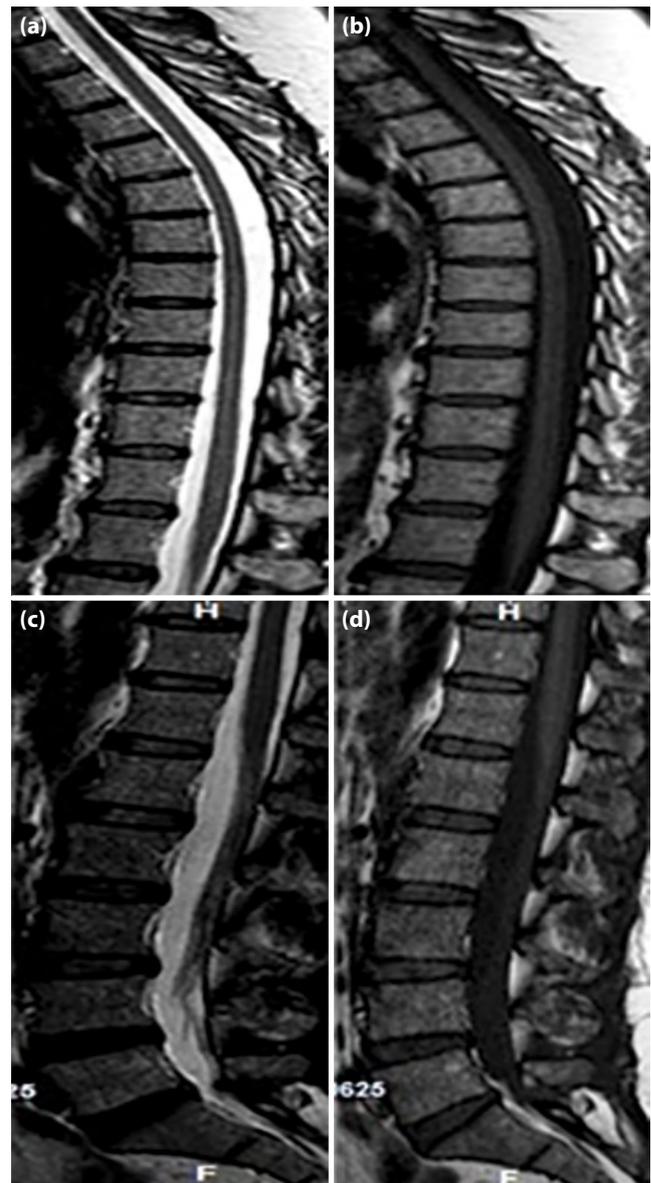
(a-d) The pre- and post-contrast thoracic and lumbar magnetic resonance imaging were normal.
